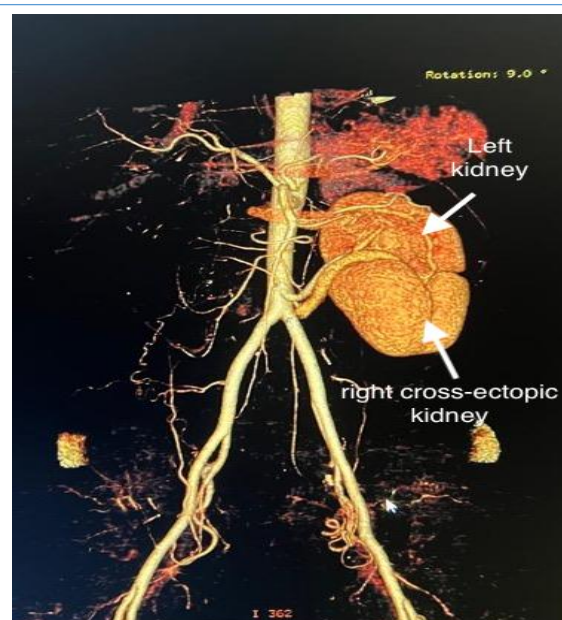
CT scan angiography showing a right to left crossed-fused renal ectopia (anterior-Posterior)
